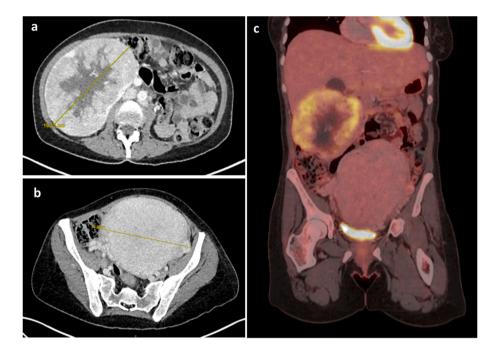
Abdominal CT. 2a. Right renal lesion of 16 cm with necrotic areas and cystic degeneration. 2b. Large myomatous uterus with a diameter of 17 cm. Fig. 2c. FDG PET-CT coronal plane with enhancement of the renal mass.
